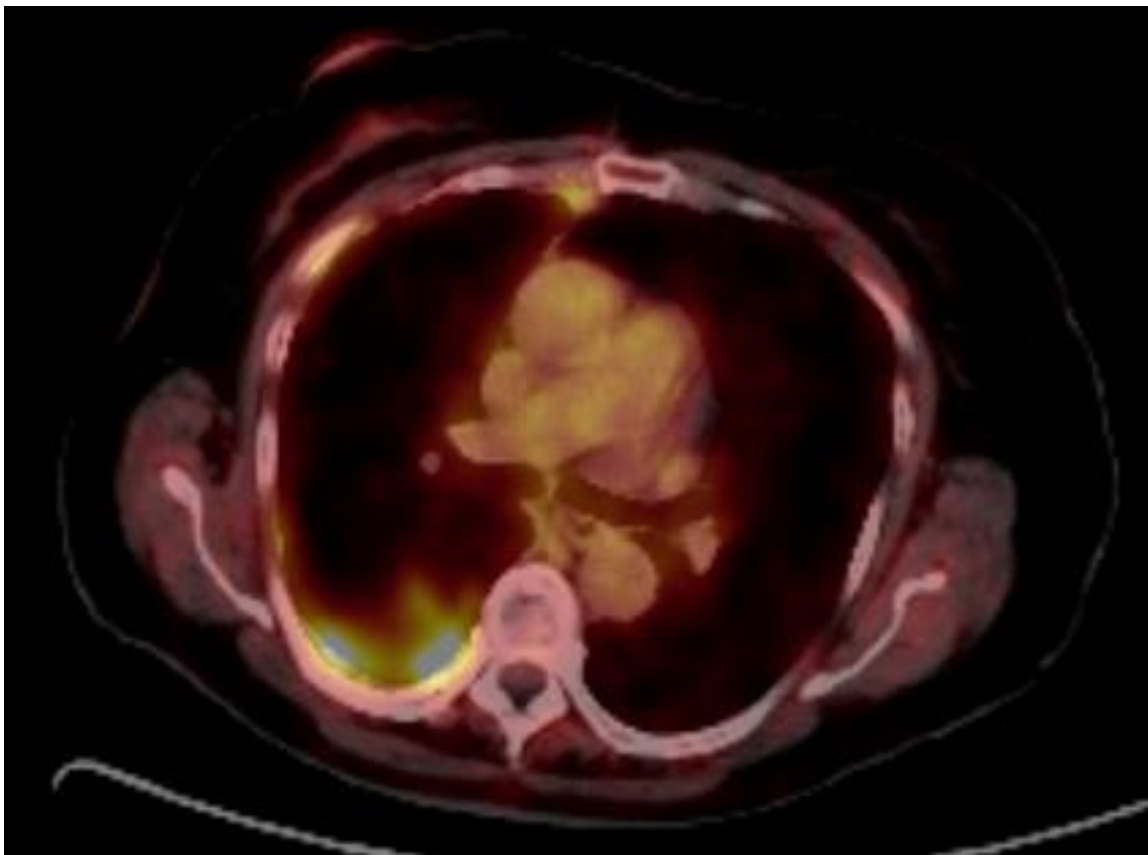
Positron emission tomography (PET) showing increased uptake along the pleural surface of the right lung, SUV values ranging up to 11.9.
